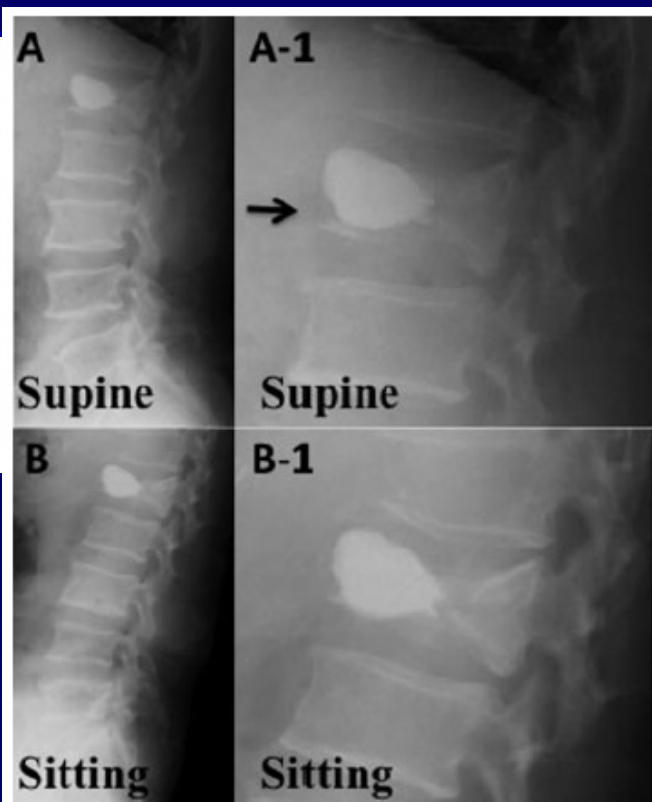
(A) Lateral X-ray taken in the supine position after balloon kyphoplasty (BKP). (A-1) Magnified X-ray that focuses on the treated vertebra. The black arrow indicates the presence of a cleft between the cement and the end plate. (B) Lateral X-ray taken in the sitting position after BKP. (B-1) Magnified X-ray that focuses on the treated vertebra. The cleft between the cement and end plate previously observed in the supine position has now disappeared.
